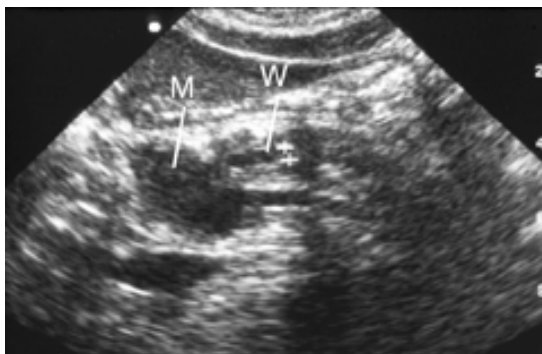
Carcinoma of the head of the pancreas. Transverse sonography upper abdomen demonstrates a hypoechoic mass (M) in head of pancreas and moderate dilatation of Wirsungian duct (W) [101]
